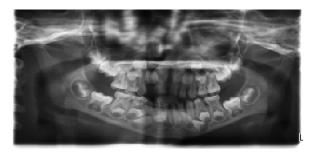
Pre-operative panoramic radiograph showed that the tooth was severely intruded [Type III] into the alveolar socket
